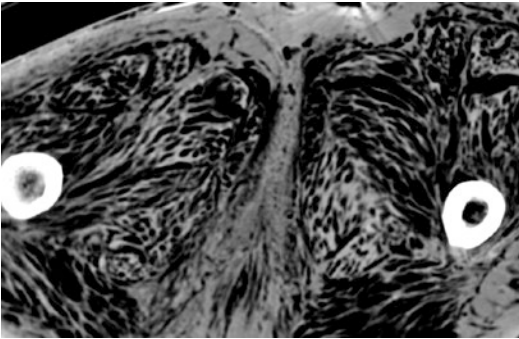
Axial CT scan shows the residual cavernous corpses in a male victim recovered from water some months after a shipwreck
